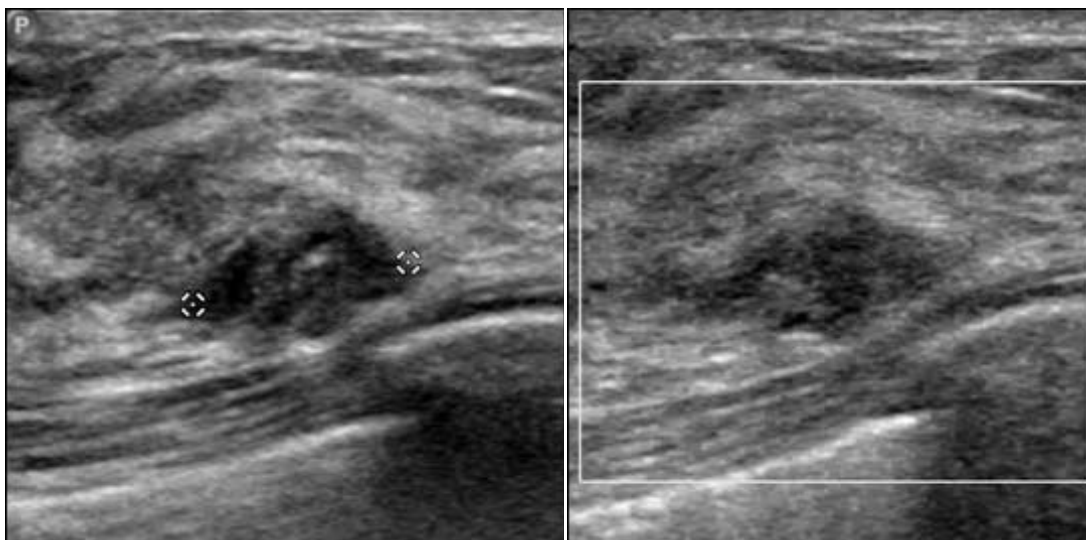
A 38-year-old female presented for check-up. (Right) Sonography showed a microlobulated hypoechoic mass at lower mid part of right breast. (Left) No intralesional vascularity is seen. Excision confirmed intraductal papilloma.
